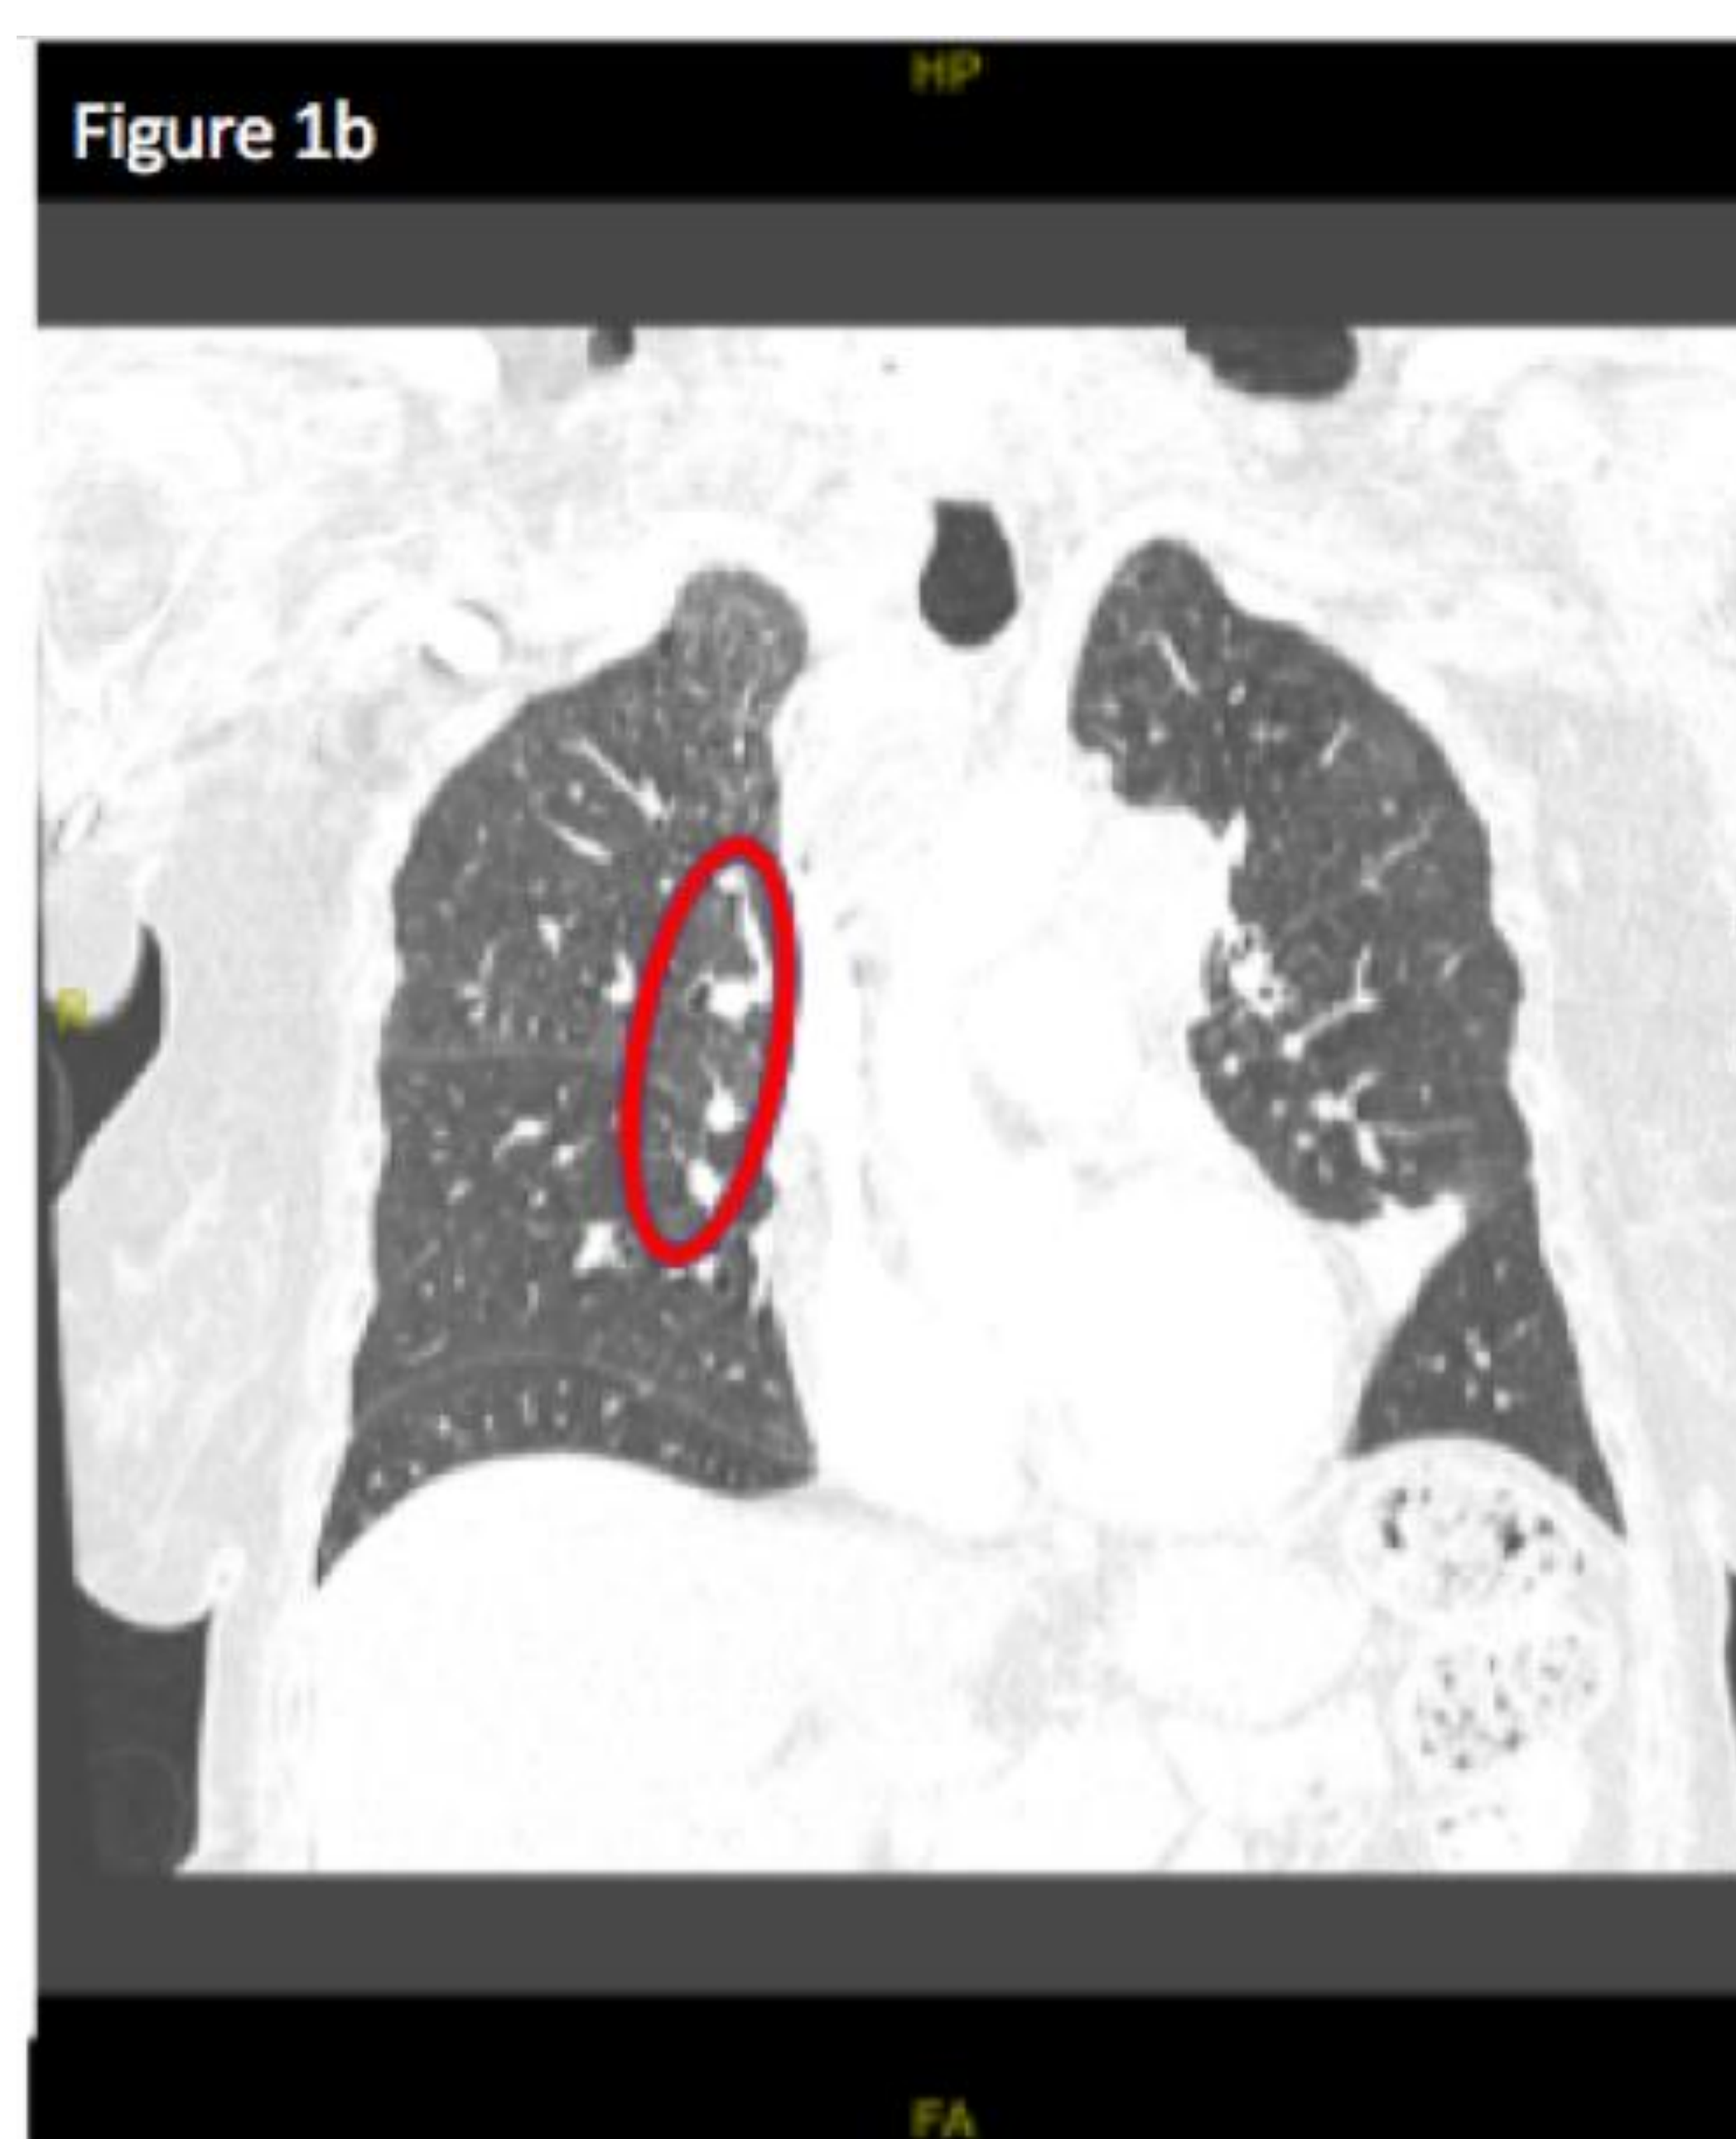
CT Chest with contrast. Figure 1a shows a right sided coin lesion shown by the red arrow. Figure 1b shows mediastinal and left and right hilar adenopathy. Right sided adenopathy is shown in the red circle.
